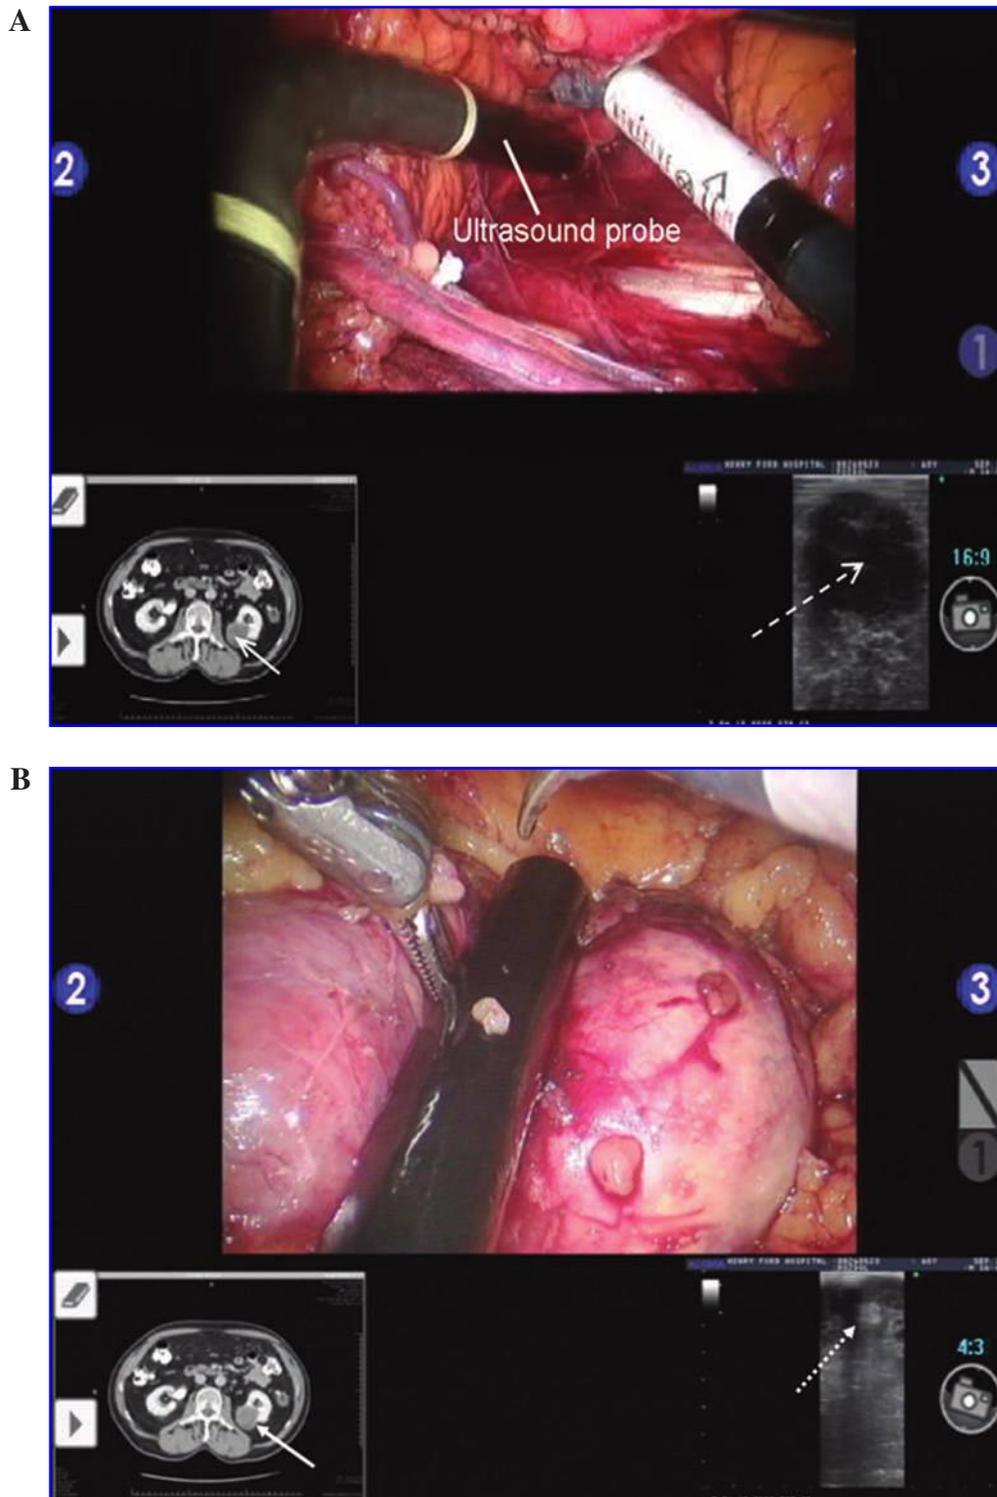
Use of TilePro during robot-assisted partial nephrectomy. (A) TilePro image demonstrating ability to simultaneously view live intraoperative ultrasonographic image (lower right, dashed arrow points to tumor) and preoperative CT image (lower left, solid arrow points to tumor) on console screen. In this instance, TilePro images were used for tumor localization to guide appropriate entry into the Gerota capsule. (B) TilePro being used to delineate tumor margins. Tumor seen on intraoperative ultrasonography (dashed arrow) and CT images (solid arrow).
